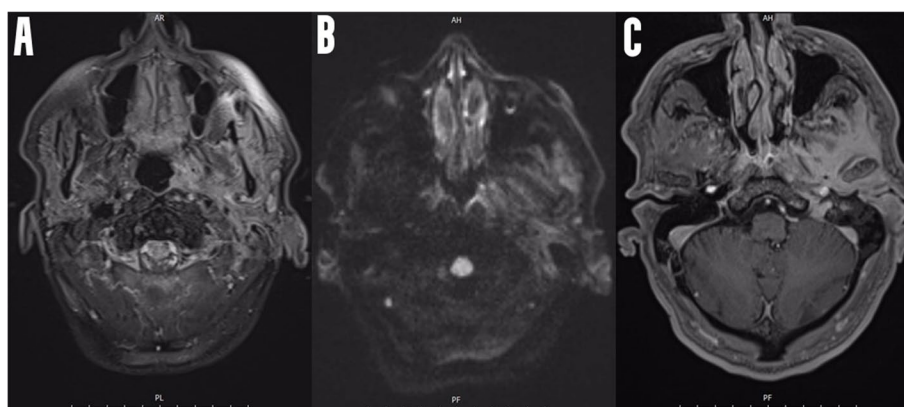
FLAIR (A), DWI (B) and T1 post-gadolinium (C) sequences revealed diffuse extensive edema and inflammation in the left ear, peri-mandibular joint, deep face spaces and pterygopalatine fossa
